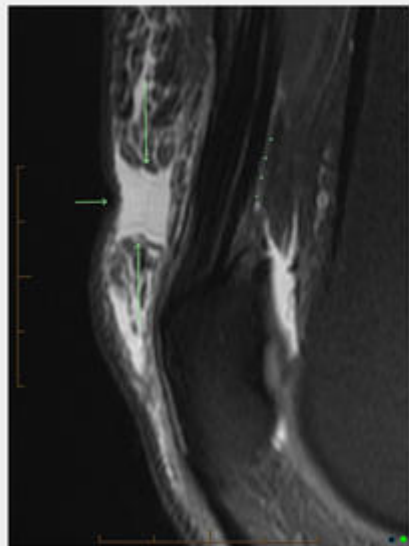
A sagittal slice of magnetic resonance imaging further reveals the fat fracture anterior to the quadriceps tendon.
